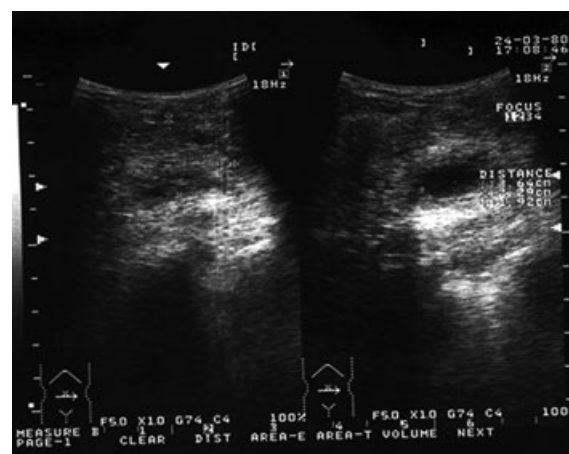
Sonography of primary left breast actinomycosis with necrotic foci.
